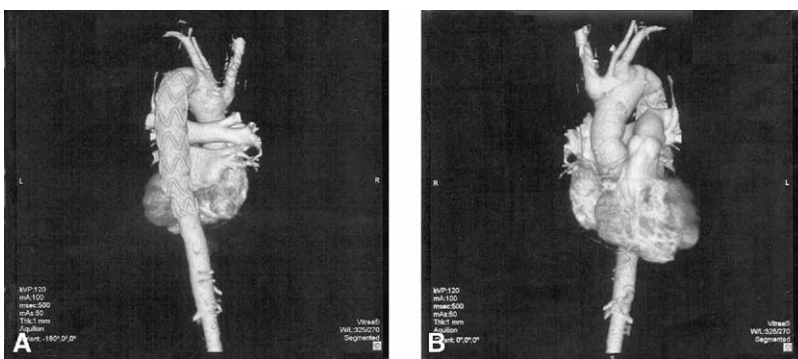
Three-dimensional postoperative computed tomographic scan of the thoracic aorta showing the stent graft/graft system. A, Anterior view; B, posterior view.
